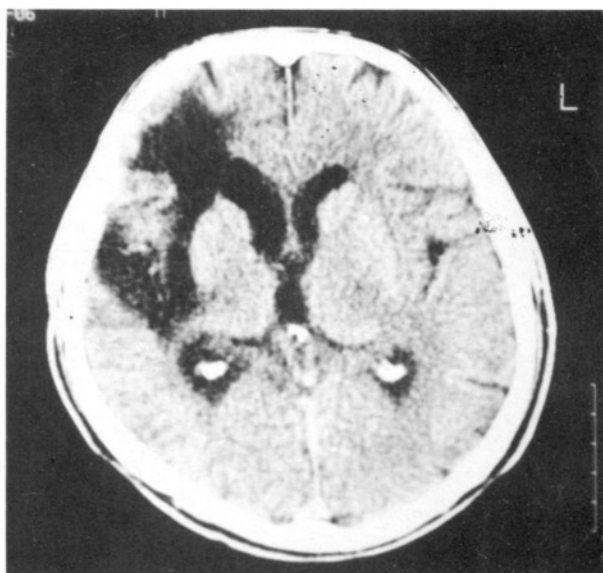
Hypodense areas and encephalomalacic sequel of the haematoma in the CT taken three years later. He is back at work as a salesman without any assistance.
